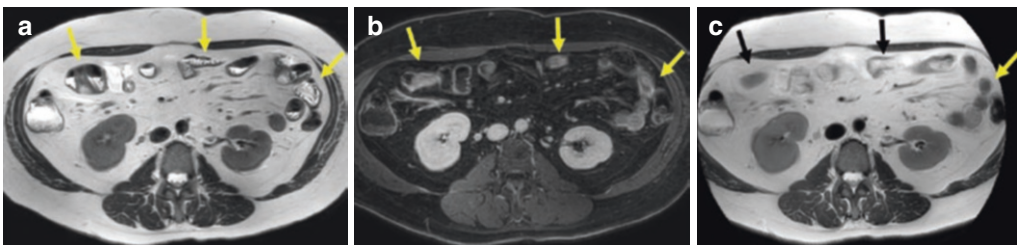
A 53-year-old woman with moderately obese body habitus, effects of fast imaging and breath-holds on peristalsis artifact (arrows): (a) breath-hold Cartesian T2-weighted (T2w) turbo spin echo single-shot technique
